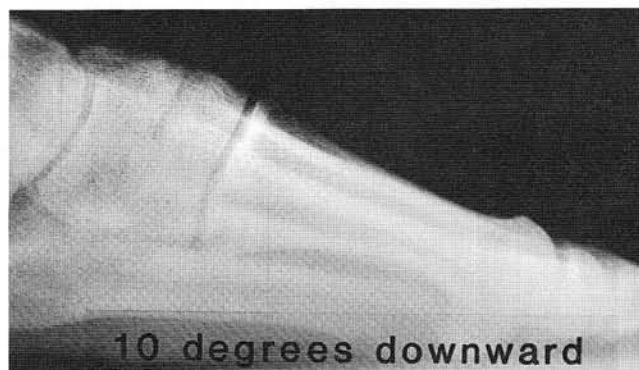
Lateral weight bearing radiograph with the tube head directed downward 10° (plantarly). Note the increased superimposition of the first and second metatarsals. The angular relationship between these two bones remains constant.
